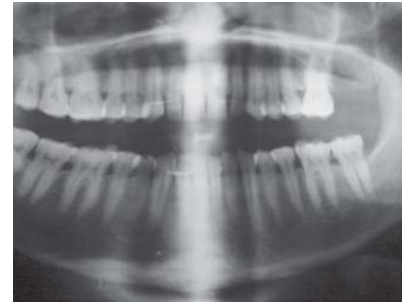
Orthopantomogram shows haziness in left posterior part of maxillary sinus
